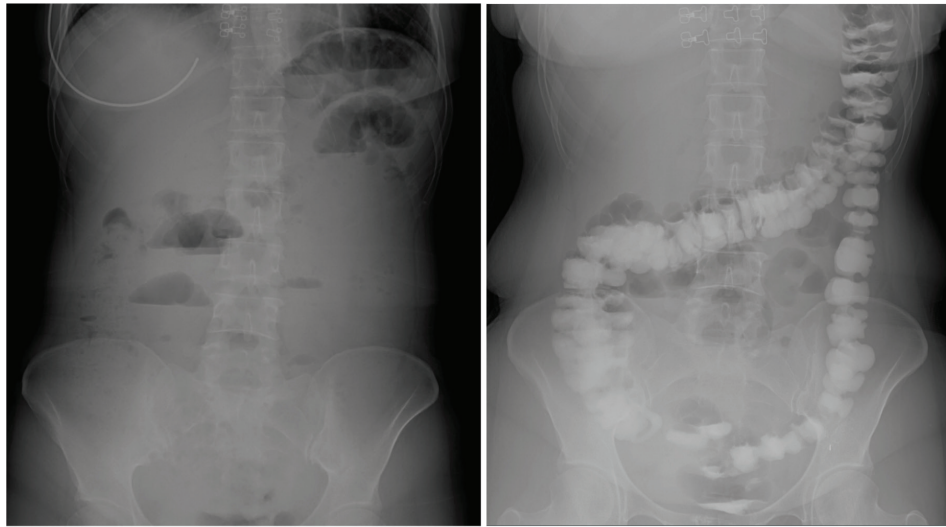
Abdominal X-ray before and after oral contrast, showing initial ileus and restoration of bowel passage following administration of oral contrast.
